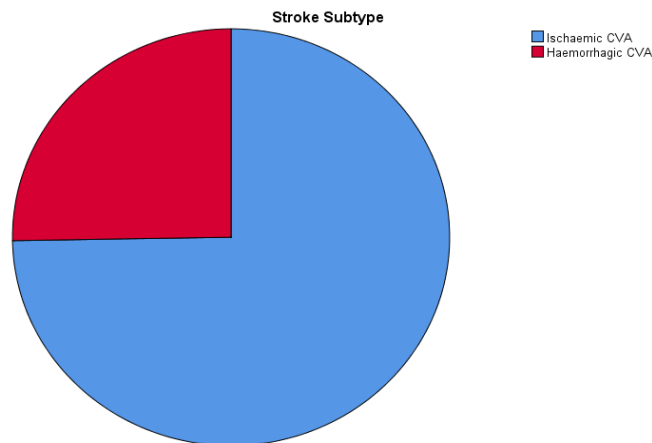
showing the distribution of participants CT Stroke diagnoses and the subtypes
